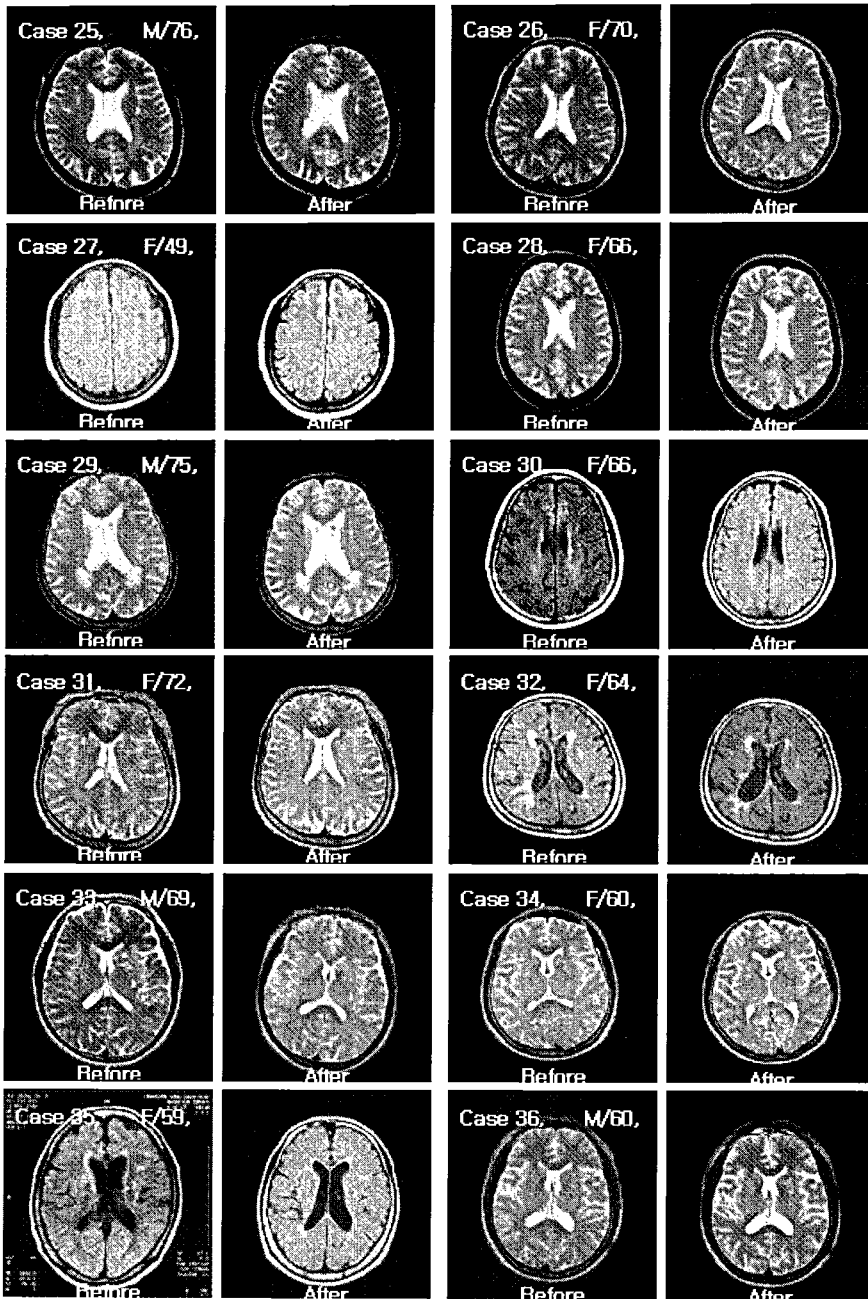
Brain MRI before and after 1 year of *Chunghyul-dan* medication in Cases 25 to 36
